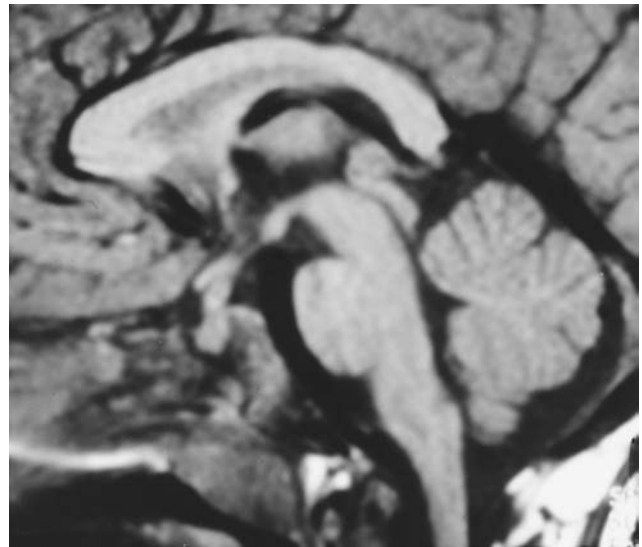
Sagittal magnetic resonance imaging scan showing thickened pituitary stalk in the same patient shown in Figure 60.3. He had a long-standing history of diabetes insipidus.
